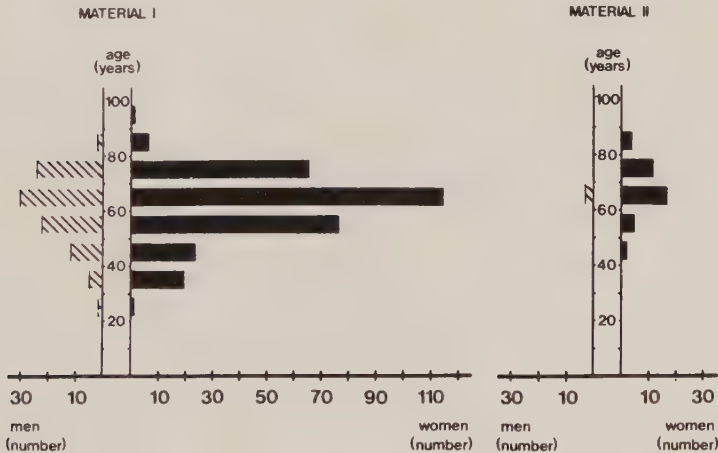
Age and sex distribution of material I comprising 407 patients with RA who had had radiography of the cervical spine performed in 1978-1980 and of material II of another 43 patients with radiography performed in 1973-1977.
